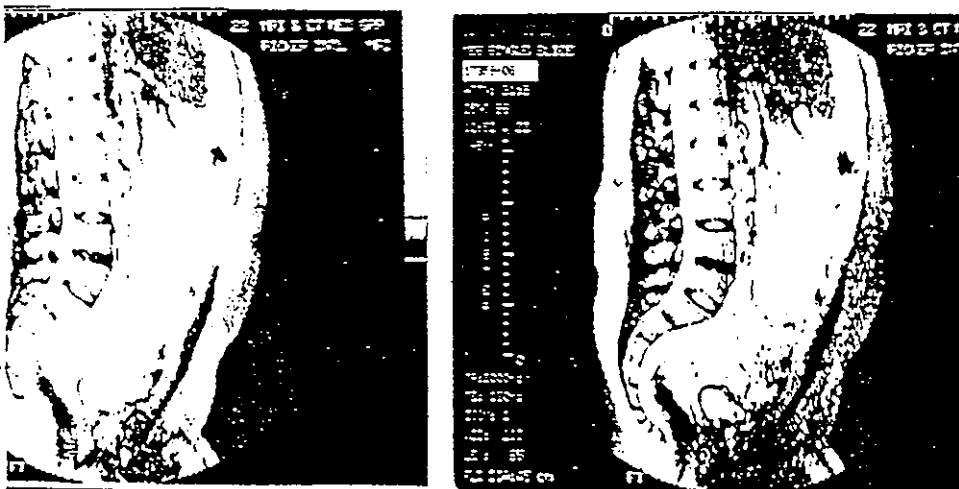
T₂-weighted MRI scan in the sagittal plane through the lumbar spine in November 1986 (after second surgery).
